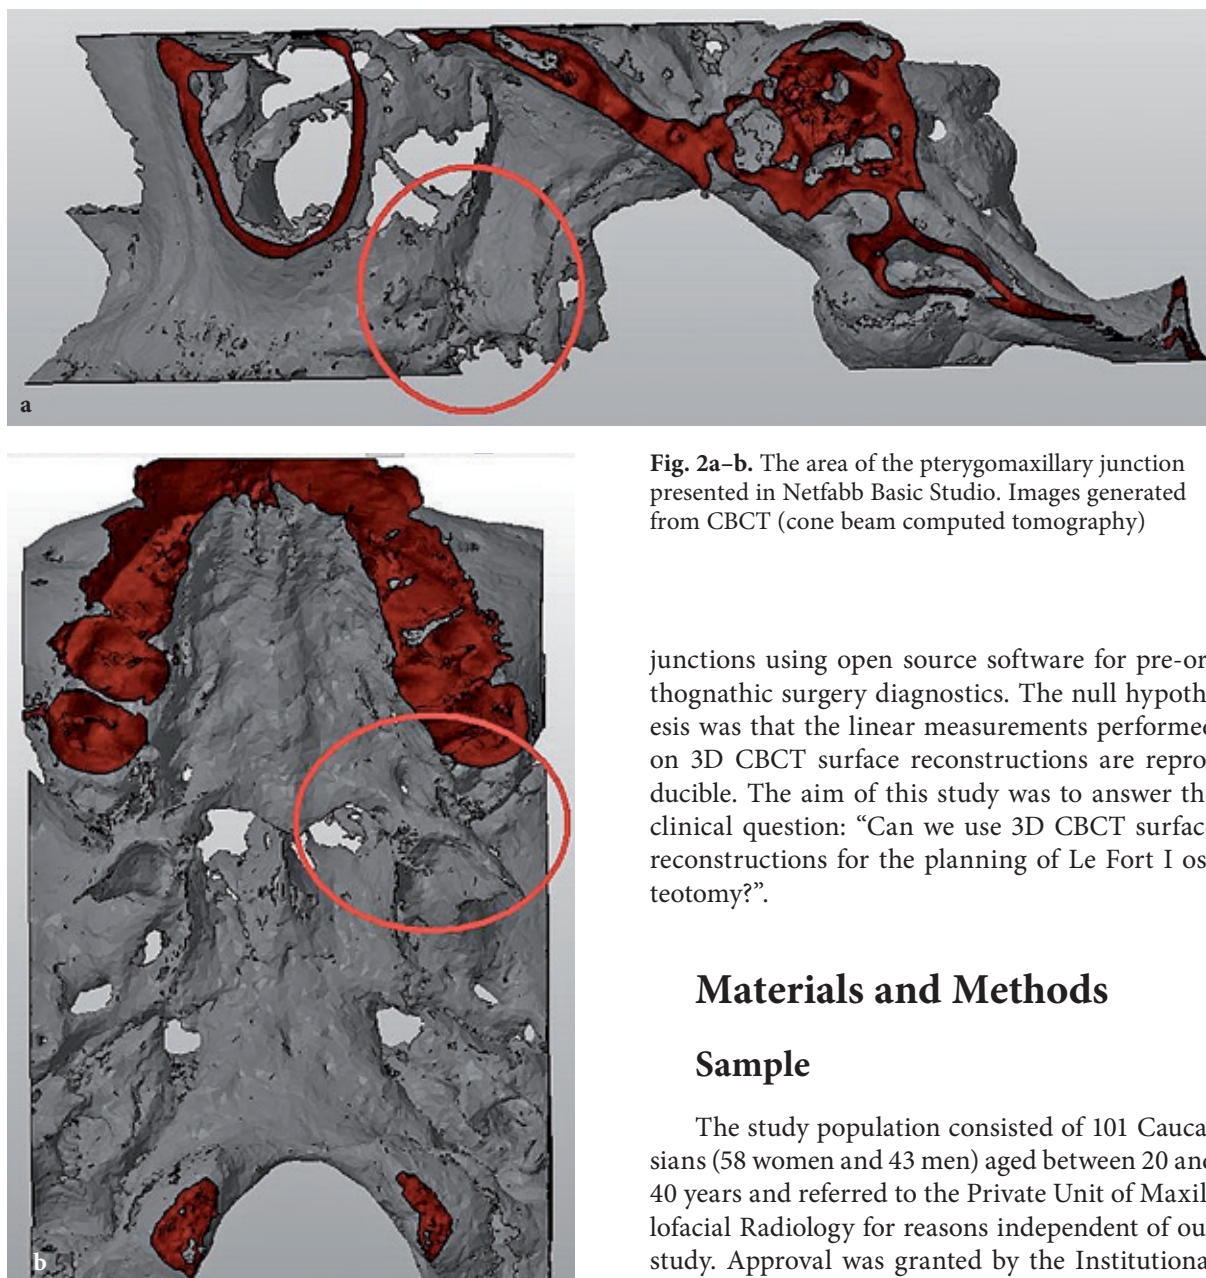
The area of the pterygomaxillary junction presented in Netfabb Basic Studio. Images generated from CBCT (cone beam computed tomography)
